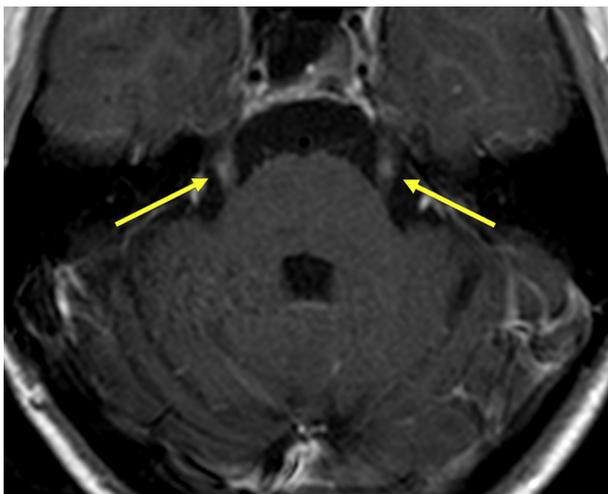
Axial T1-weighted post-contrast image demonstrates subtle bilateral trigeminal nerve enhancement (arrows).
